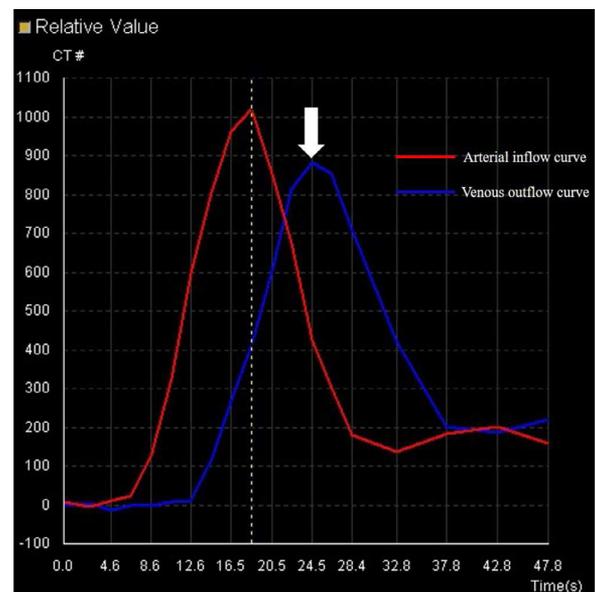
The graph shows the time-density dynamic distribution curve. The horizontal axis is the time axis, the vertical axis is the CT value. The peak value of the venous curve indicated by the white arrow is the venous phase, and the area after the peak of the venous curve is the late venous.
